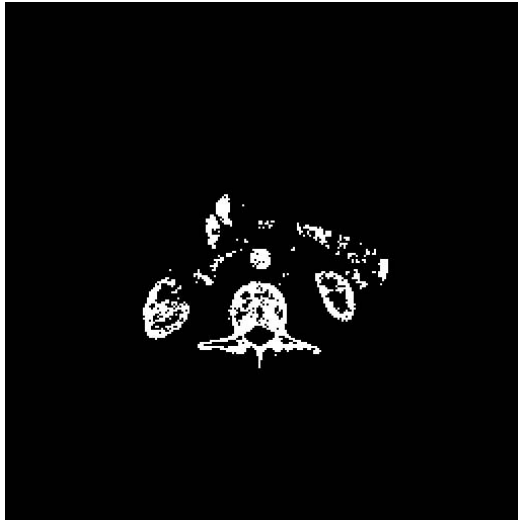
Sample results for extracting the pelvic region from the raw CT Image.
